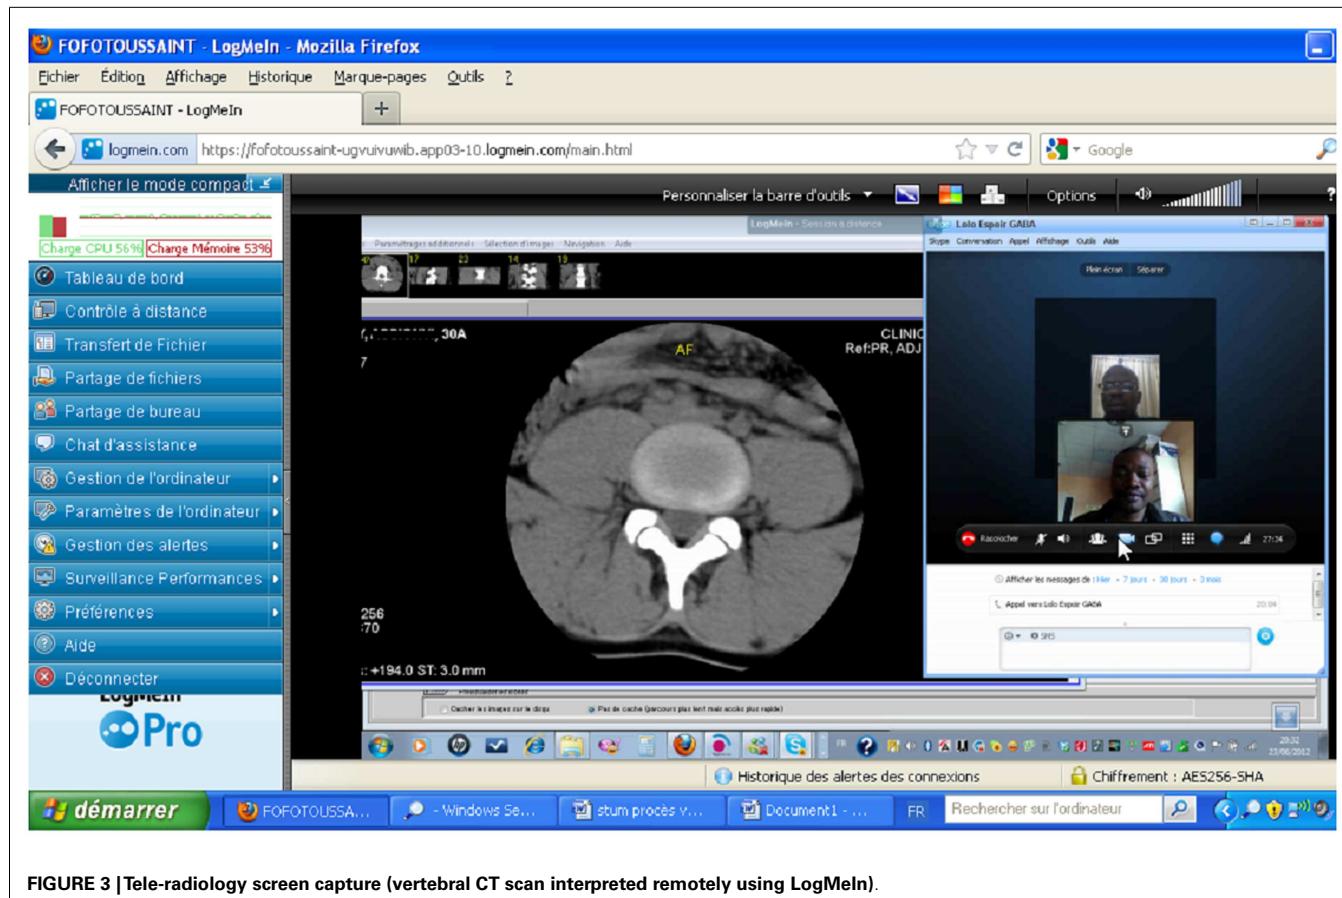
Tele-radiology screen capture (vertebral CT scan interpreted remotely using LogMeIn).
